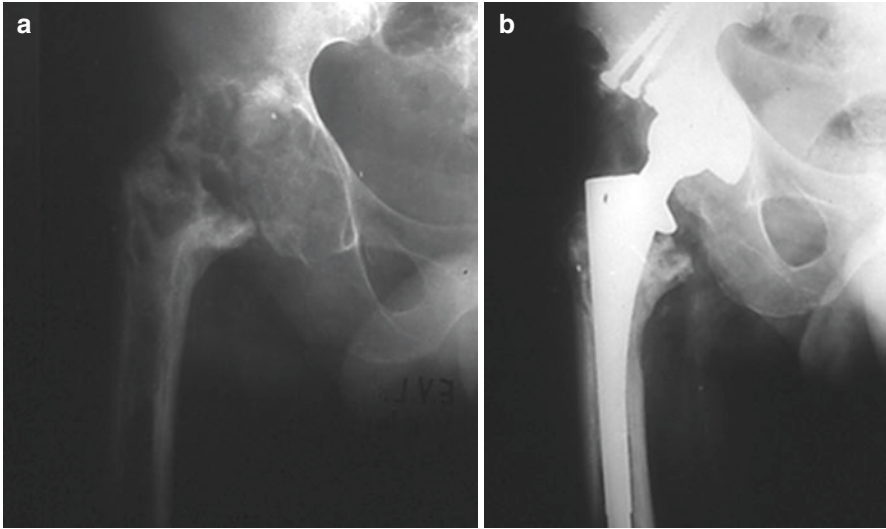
(a) preoperative radiograph of a hip shows a resection-arthroplasty. (b) Radiographs show structural allograft taken from the femoral head to reconstruct the acetabular roof. The bone allograft provided mechanical support for the skeleton with a good clinical outcome
